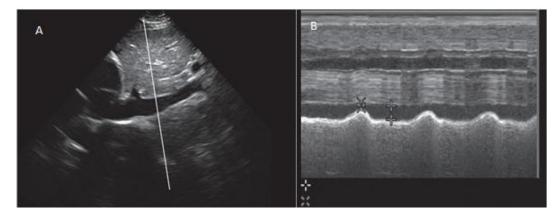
Measurement of IVC diameter a long-axis view of the IVC. IVC diameter is measured by M-mode on ultrasound 2-3 cm distal from where the hepatic vein joins IVC; B-M-mode demonstration of changes in the diameter of the respiratory cycle
